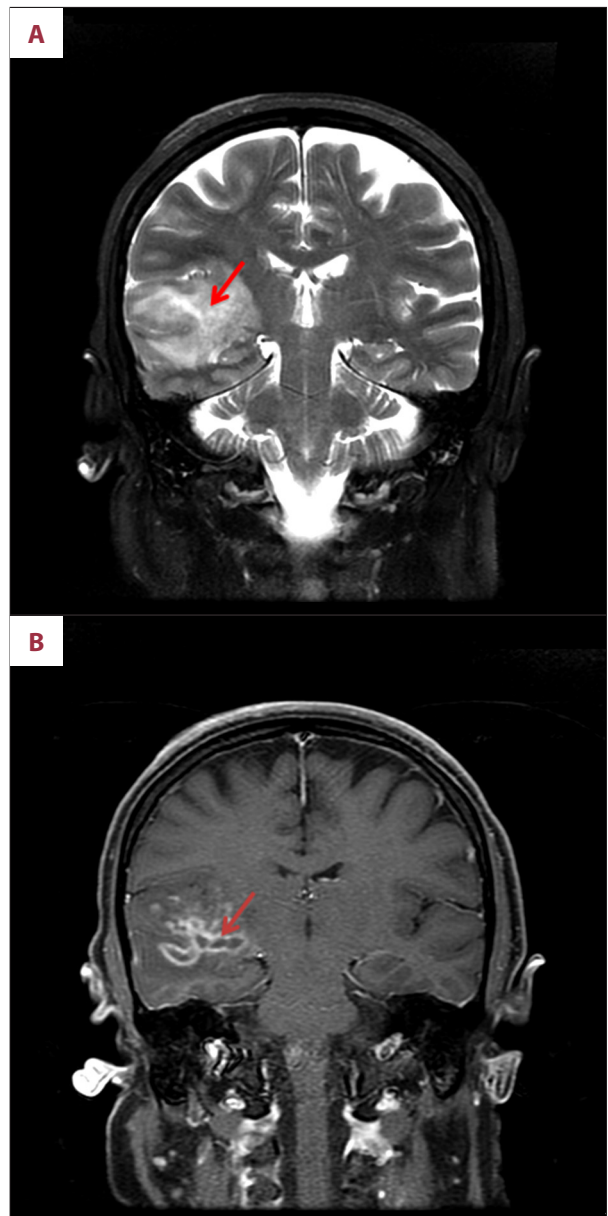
Brain MRI, next day of presentation to the emergency room. (A) Preoperative MRI scan, T2 coronal window, showing a large abscess in the right temporal lobe surrounded by extensive vasogenic edema. (B) MRI of the brain, T1 weighted images with gadolinium, coronal window showing multiple abscesses in the right temporal.
